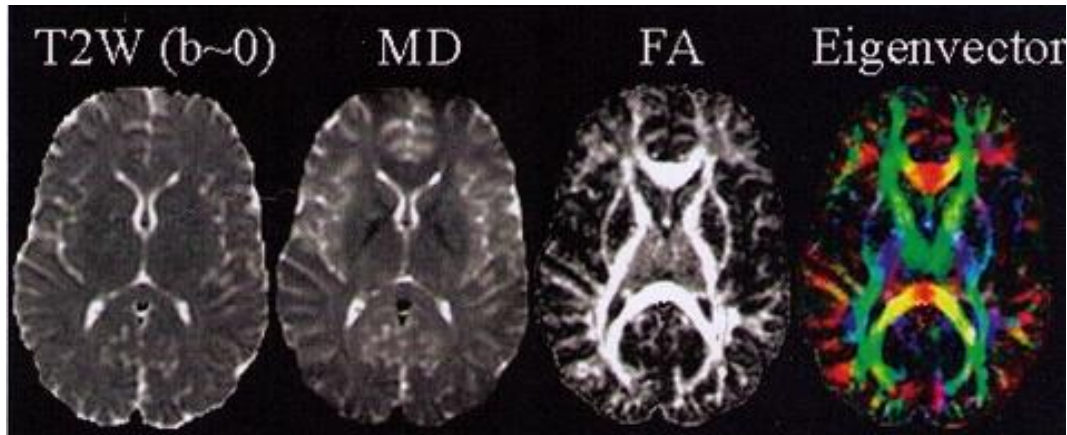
Quantitative maps of DTI measurements. Left to right: T2-weighted reference image (i.e. $b=0$ s/mm²), the mean diffusivity (MD), fractional anisotropy (FA; hyperintense in white matter), the major eigenvector direction indicated by RGB colour map (red: right-left; green: anterior-posterior; blue: superior inferior).(22)
